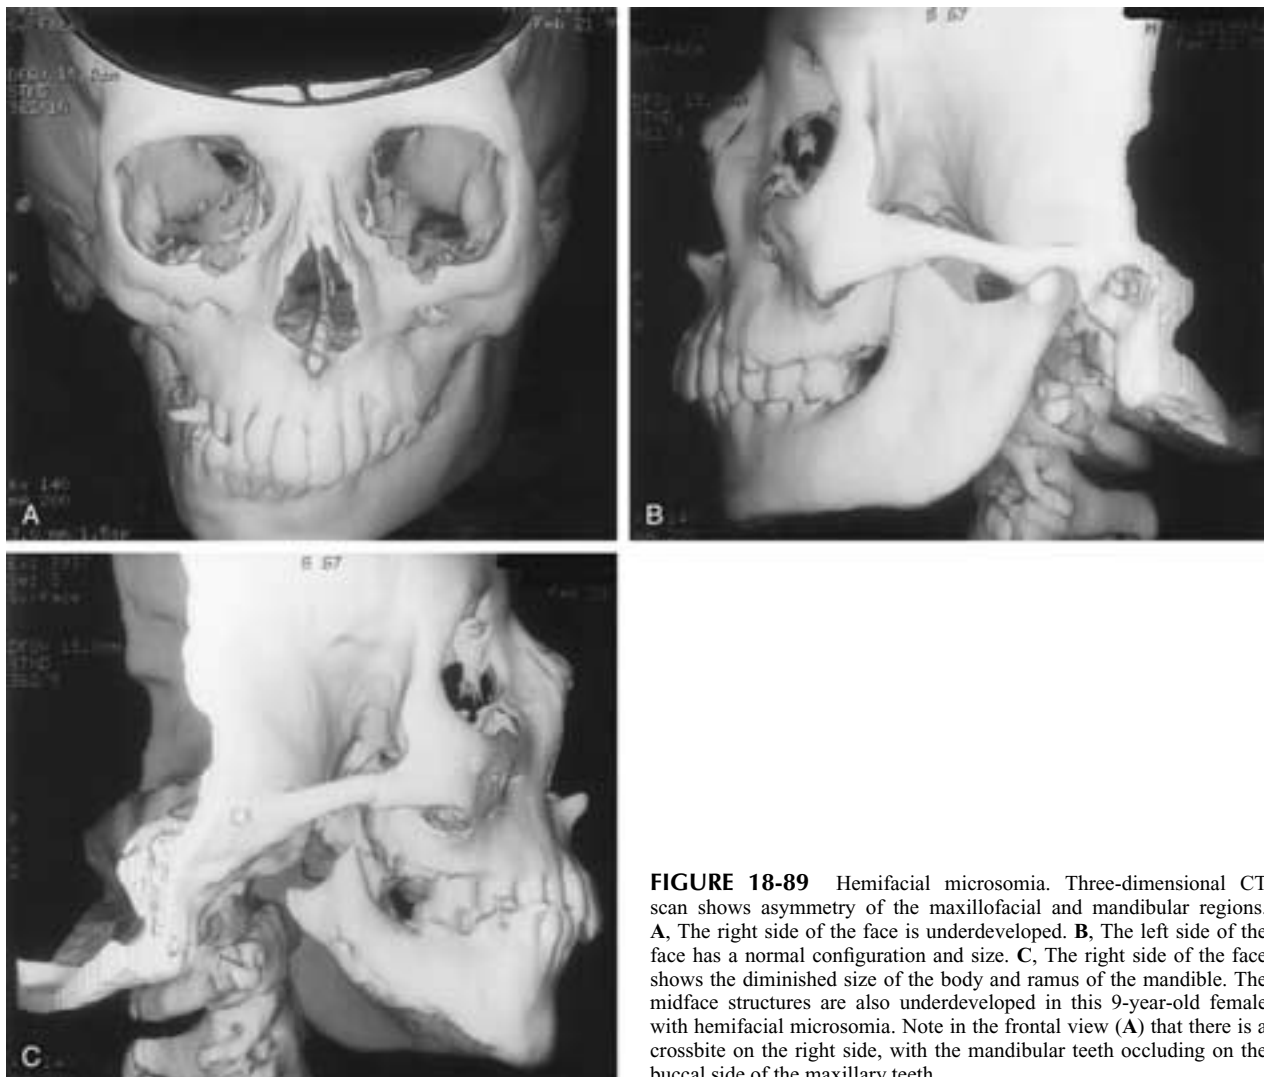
Hemifacial microsomia. Three-dimensional CT scan shows asymmetry of the maxillofacial and mandibular regions. A, The right side of the face is underdeveloped. B, The left side of the face has a normal configuration and size. C, The right side of the face shows the diminished size of the body and ramus of the mandible. The midface structures are also underdeveloped in this 9-year-old female with hemifacial microsomia. Note in the frontal view (A) that there is a crossbite on the right side, with the mandibular teeth occluding on the buccal side of the maxillary teeth.
